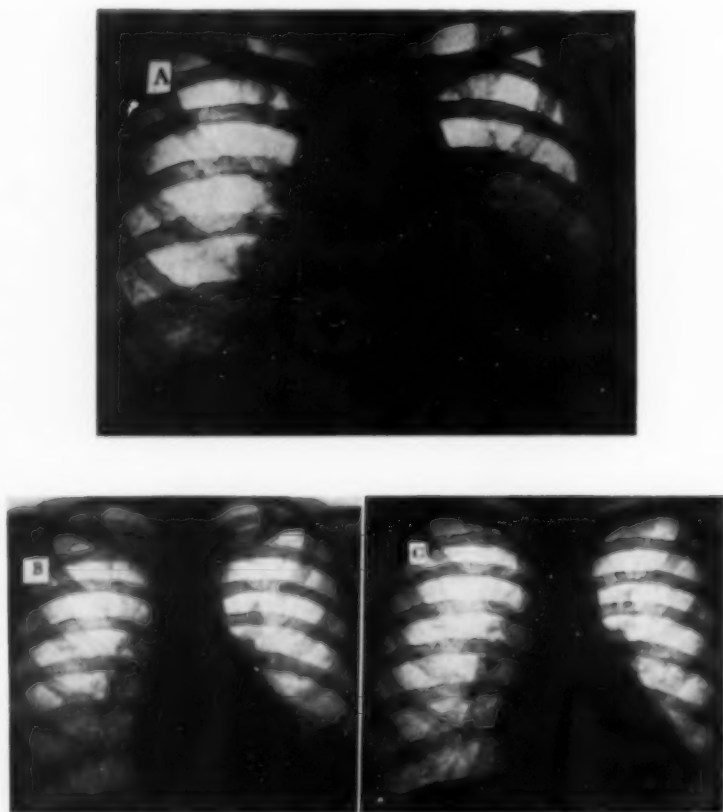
(Case No. 9) Effect of local hydrocortisone acetate on pericardial and pleural effusions: (A) Roentgenogram before treatment. (B) 5 days after the introduction of 75 mg of hydrocortisone into the pericardial cavity. (C) 8 days after a second introduction of 100 mg of hydrocortisone into the left pleural cavity: complete recovery.
